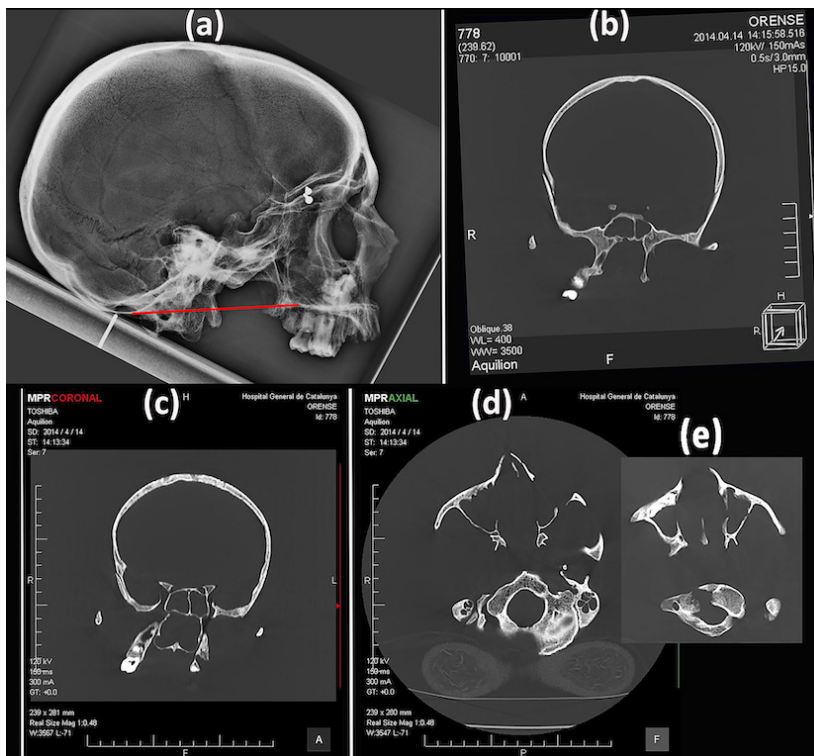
a) Conventional radiographic image. McGregor's line (red line). b) CT image. Frontal view. Deviation of the pterygoid processes. c) CT image. Frontal view. Deviation of the maxillary bone and the nasal cavity d) and e) CT image. Inferior view. Stenosis of the vertebral canal at the level of the *foramen magnum*.
